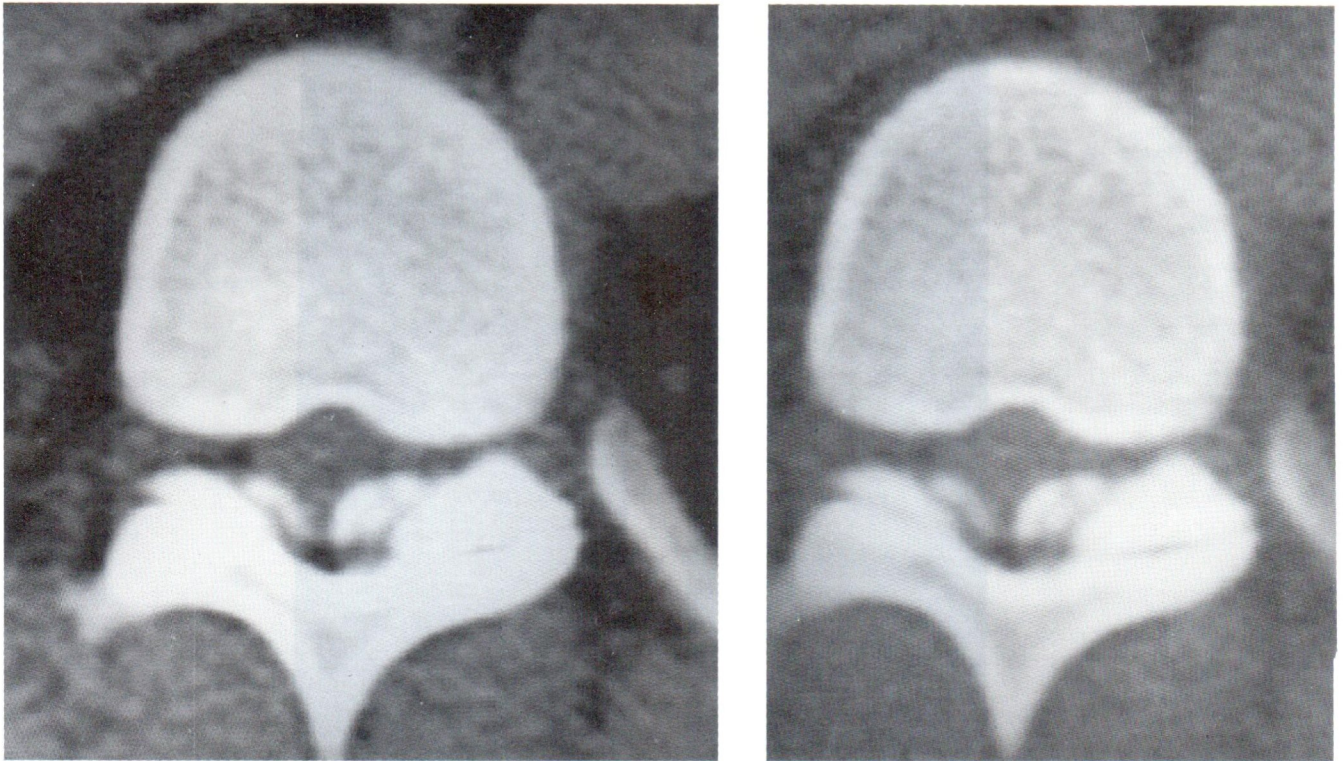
Axial CT scan of the involved level showed calcified or ossified the thickened ligamentum flavum on both sides with cord compression.
